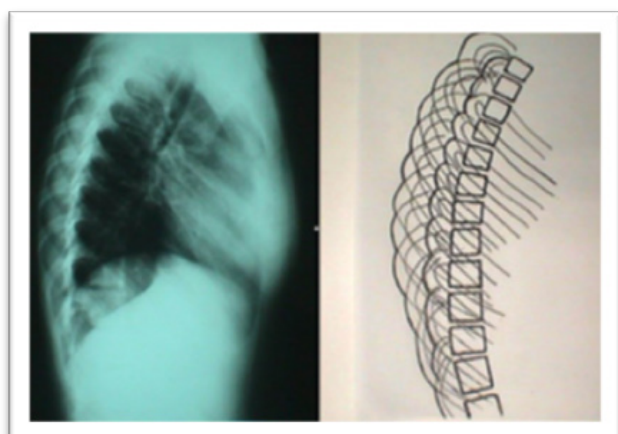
The way the segmental RI (SRI) is assessed on the standing lateral spinal radiographs.<sup>65</sup>
